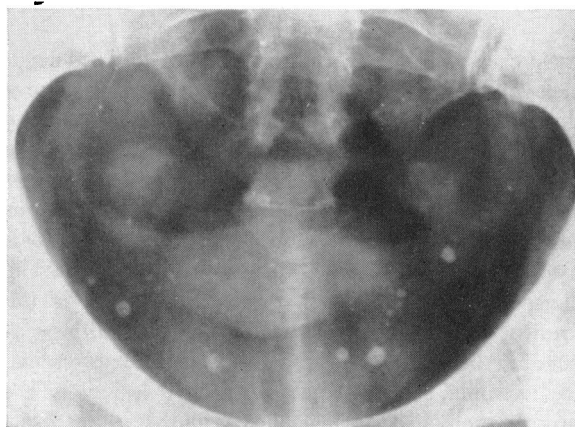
Plain film showing normal soft-tissue pelvic structure in a female.
